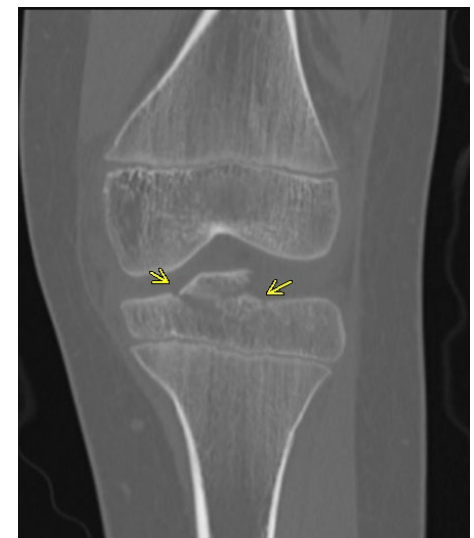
CT of Type III tibial spine avulsion fracture
